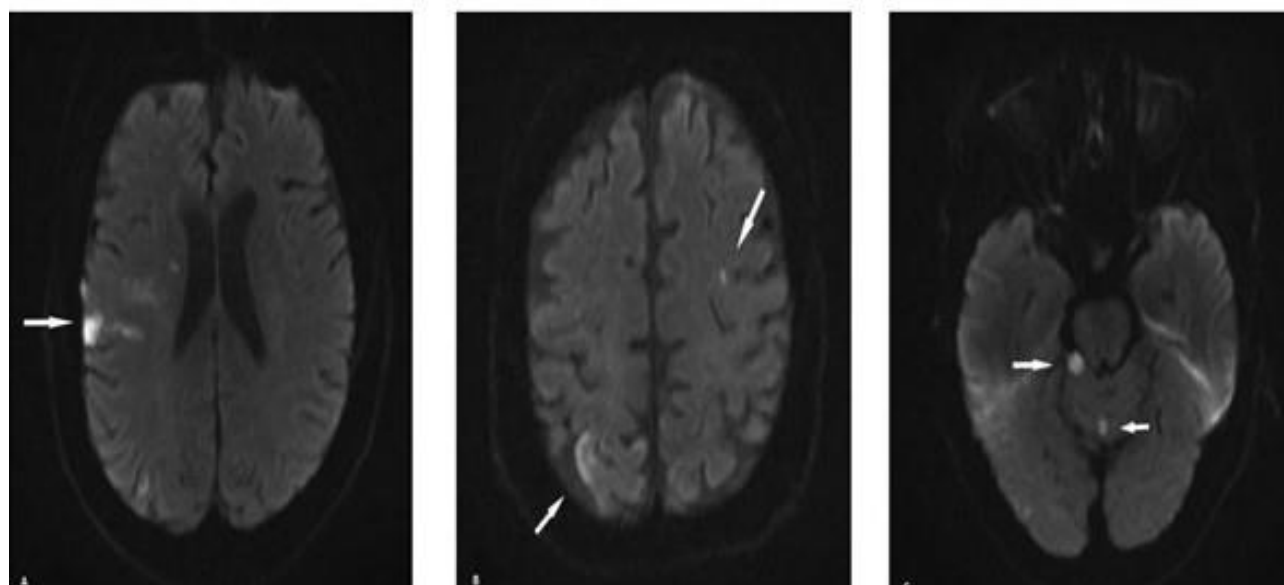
Diffusion weighted MRI brain showing acute infarctions in (a) right MCA territory, (b) right PCA territory and (c) vermis and right cerebellar peduncles.
